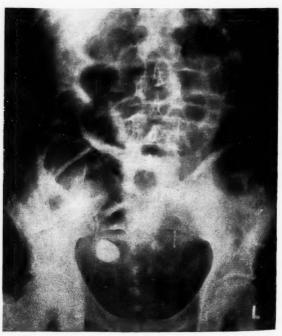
Supine radiograph showing distended coils of small intestine and the opacity in the pelvis due to the large fæcolith.
